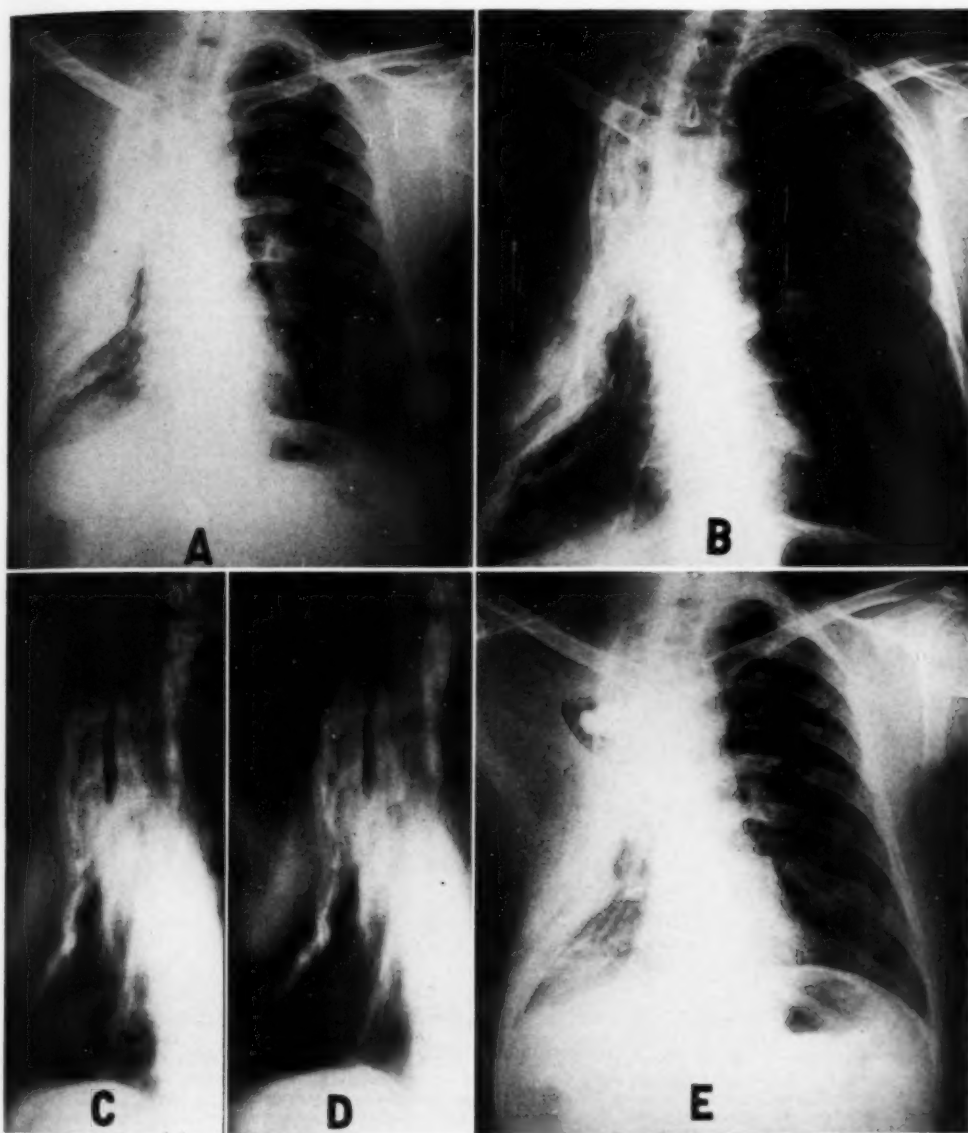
A. Post-thoracoplasty roentgenogram with indefinite lateral convexity in the conventional film; sputum positive. B. Bucky roentgenogram of same patient showing bony detail and definite "lateral convexity." C and D. Tomographic roentgenogram of same patient at levels 7 and 9 cm. showing definite "lateral convexity" and slit-like cavity. E. Roentgenogram following open drainage of tuberculous cavity. Gauze pack impregnated with iodized oil confirms location of cavity on film. Preoperative intracavitary manometric readings were -3, -8.
